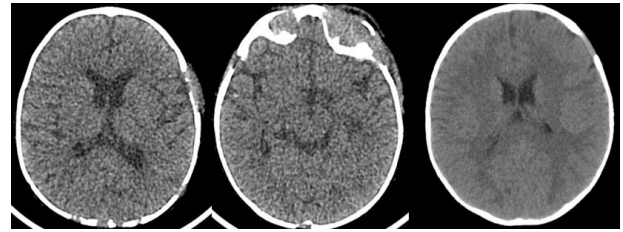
The following axial computed tomography images of the brain reveal multiple osteolytic, punched-out lesions lacking a sclerotic rim, with full-thickness bone destruction involving all bones of the skull.
